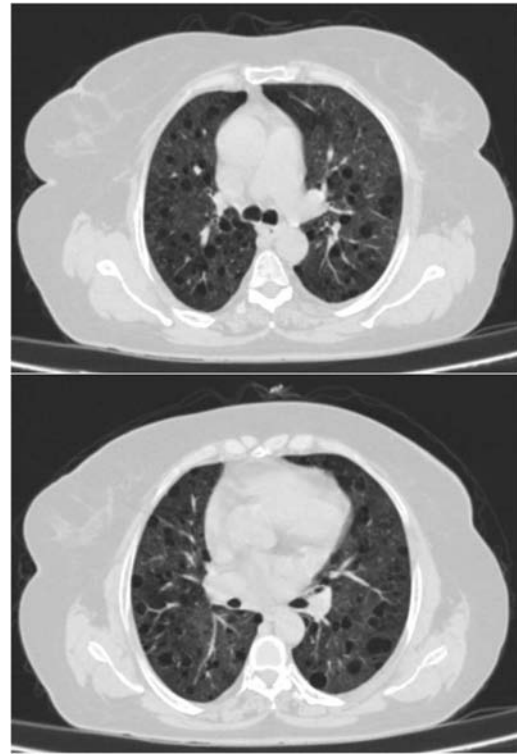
High-resolution computed tomography scans of the lungs showing widespread thin-walled bilateral cysts in a background of normal parenchyma.
